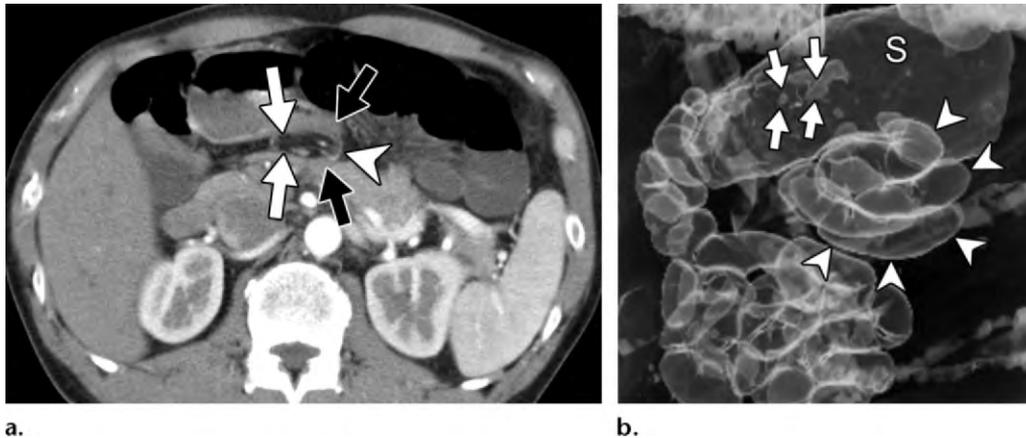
Lesser sac hernia through the lesser omentum in a 44-year-old man who presented with acute abdominal pain. (a) Axial contrast-enhanced CT image shows converging mesenteric vessels and fat (white arrows) intersecting the distal part of the stomach (black arrows) and the right gastric artery (arrowhead). Traction and distortion of the distal part of the stomach are also seen. (b) Transparent volume-rendered CT image shows a cluster of intestine (arrowheads) in the lesser sac, with a beak shape (arrows) pointing toward the lesser curvature of the stomach (S). Surgery confirmed herniated intestine in the lesser sac protruding through a defect in the lesser omentum. (Case courtesy of Yasuhiro Iseki, MD, Osaka City University Graduate School of Medicine, Osaka, Japan.)
